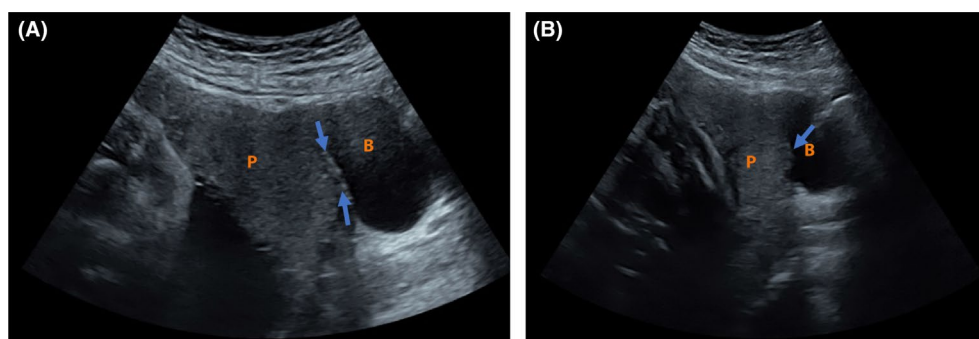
Ultrasound image at 28 weeks of pregnancy showing a sagittal view of the lower uterine segment. B, bladder; P, placenta. (A) Myometrial thinning and (B) mild placental bulging.
